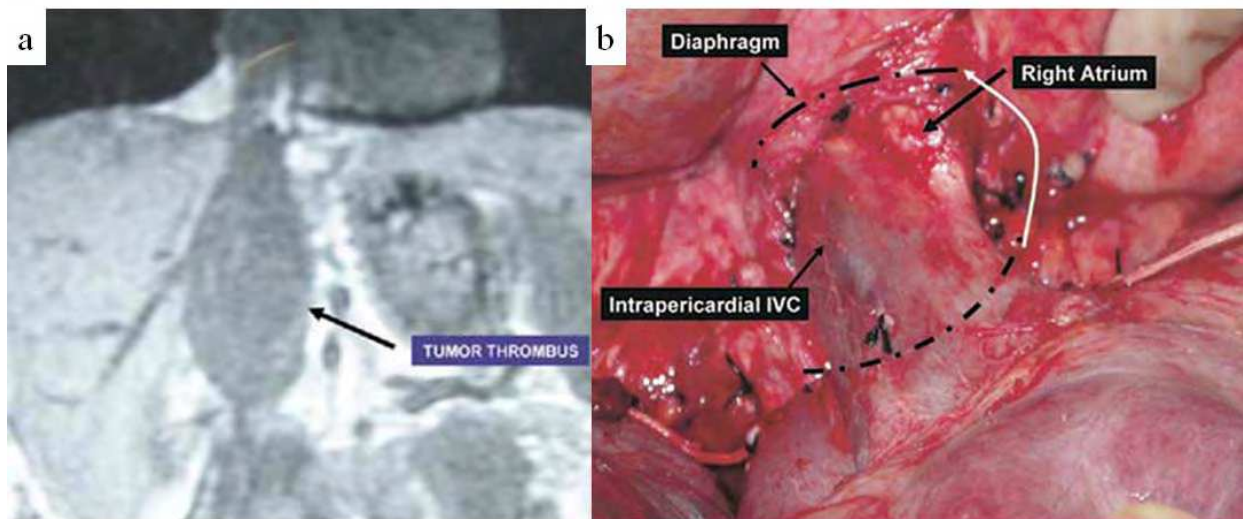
Ciancio's technique (9). (a) Magnetic resonance imaging of RCC. Arrow indicates tumor thrombus in IVC extending above diaphragm into right atrium. (b) Diaphragm dissected off suprahepatic IVC. Intrapericardial IVC and right atrium exposed through abdominal cavity.
